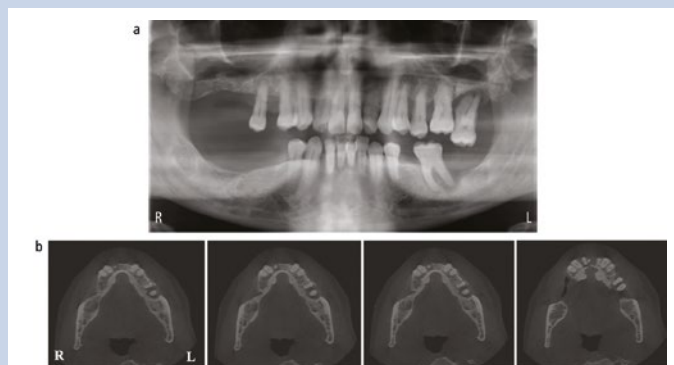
Case one, OPG vs. CBCT-50-year-old, considering potential implants predominantly in the lower jaw; 1b The CBCT shows significant bone loss especially in the lower right quadrant
